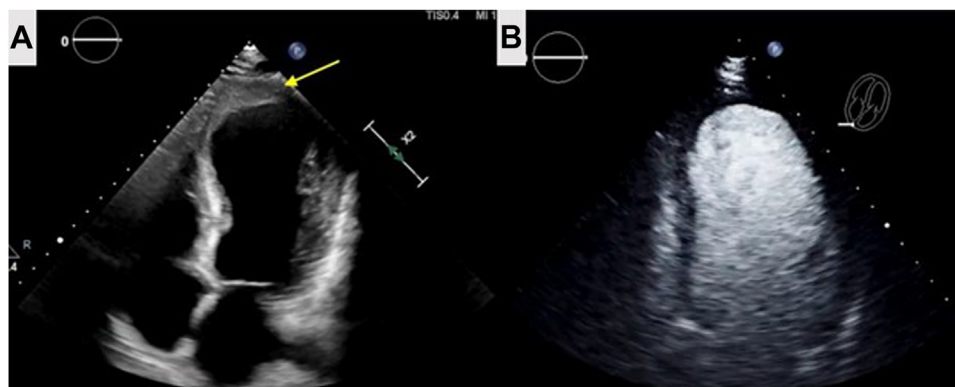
TTE. (A) Apical four-chamber view without ultrasound enhancing agent at 3-month follow-up. The LV thrombus is reduced in size to 2.9×0.7 cm (arrow). (B) Apical four-chamber view with ultrasound-enhancing agent at 8-month follow-up. The LV thrombus is no longer present.
